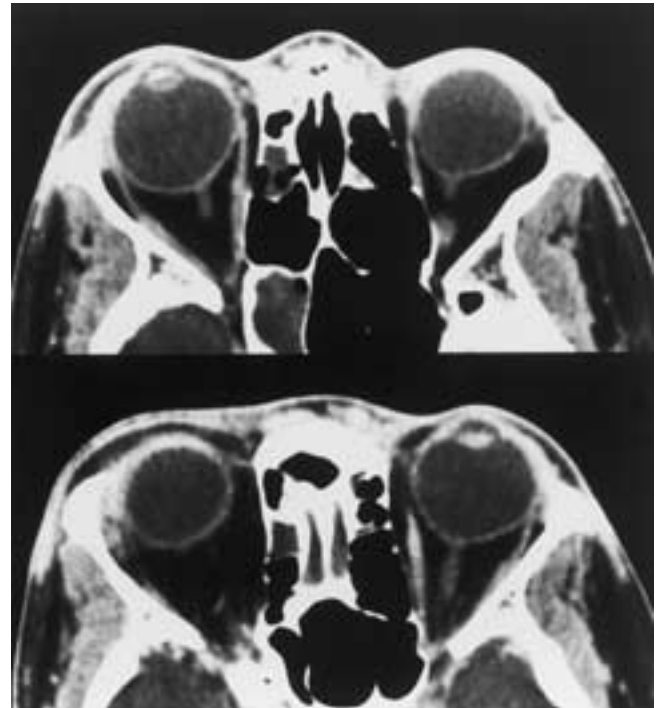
Glaucoma and enlarged eye. Axial CT scans shows moderate enlargement of the right globe (top). This child presented with eye pain and was found to have cataracts, anterior uveitis of unknown etiology, and glaucoma on the right side. Note the irregularity of the right lens as well as a shallow right anterior chamber (bottom).
